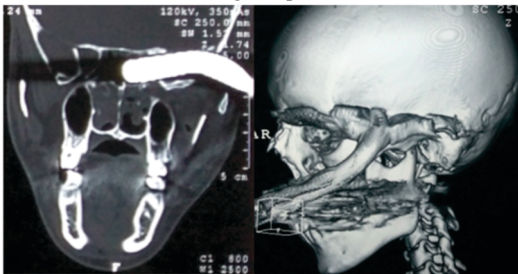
(a) CT bone window coronal image showing metallic foreign body penetrating left temporal region along skull base. (b) 3-D CT image showing metallic foreign body going into left temporal region.
